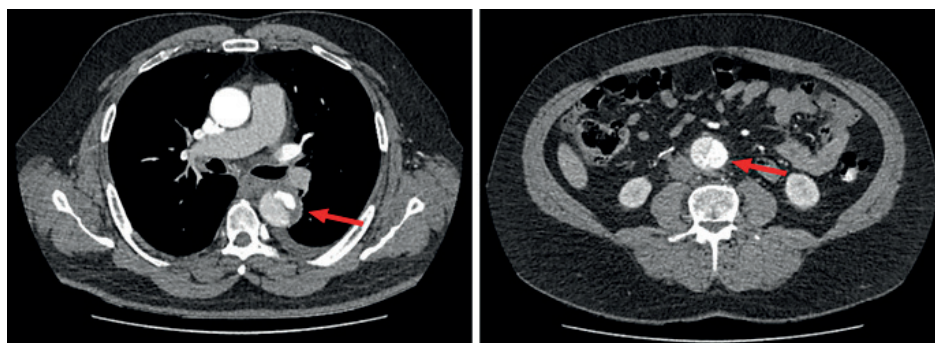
Initial CTA scan images showing the aortic dissection (Stanford type B) at two different levels
